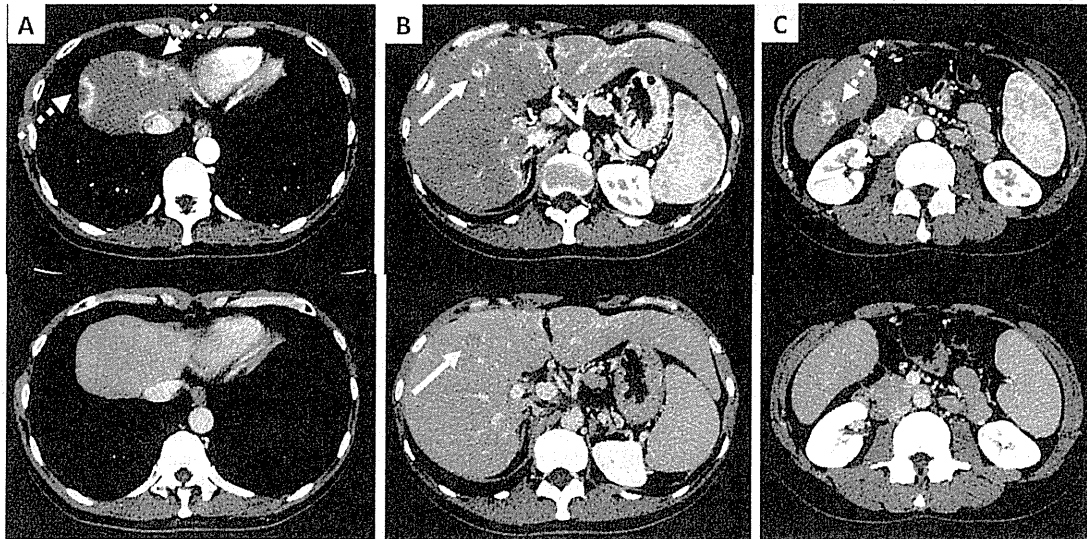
Contrast-enhanced dynamic CT revealing hyperattenuation in the arterial phase and hypoattenuation in the equilibrium phase in the nodule that was finally diagnosed as cHCC-CC (Panel B, arrow). Other nonneoplastic lesions showed ring-enhancement in the arterial phase without hypoattenuation in the equilibrium phase (Panels A and C, dotted arrow). In each panel, upper image is arterial phase, and lower image is equilibrium phase.
